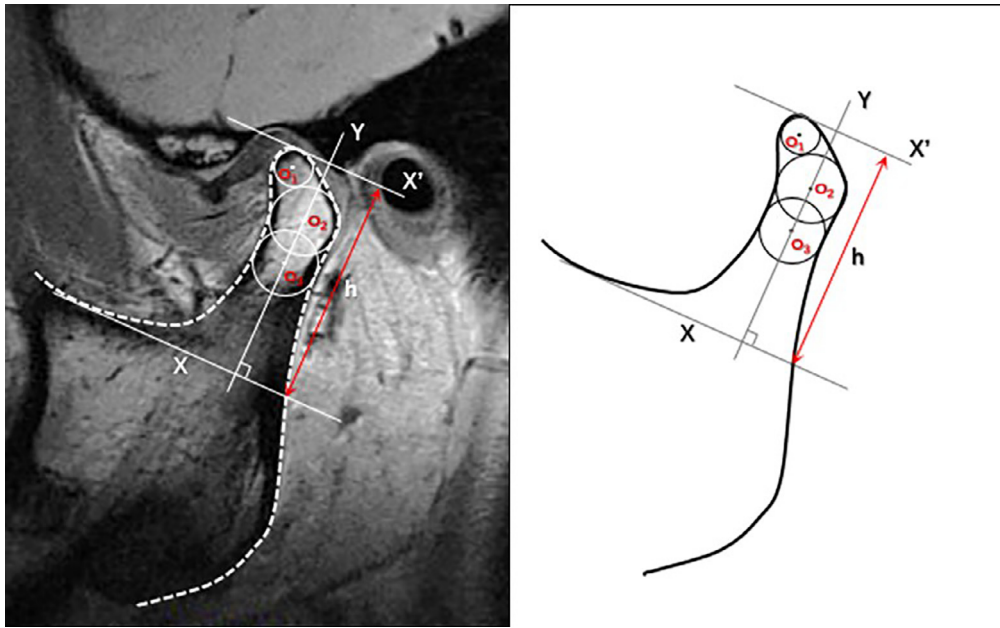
Measurement of condylar height on magnetic resonance imaging (MRI).
